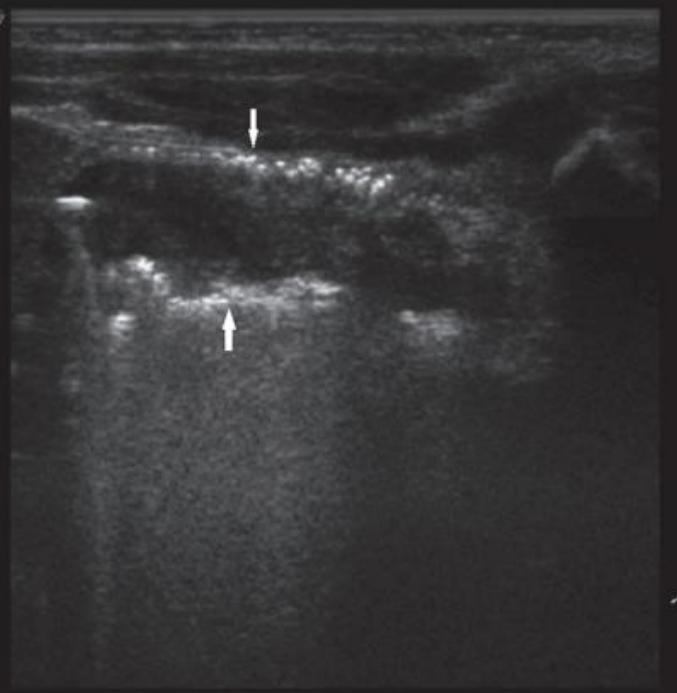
Ultrasound image of intestinal pneumatosis of large intestine (arrows).
